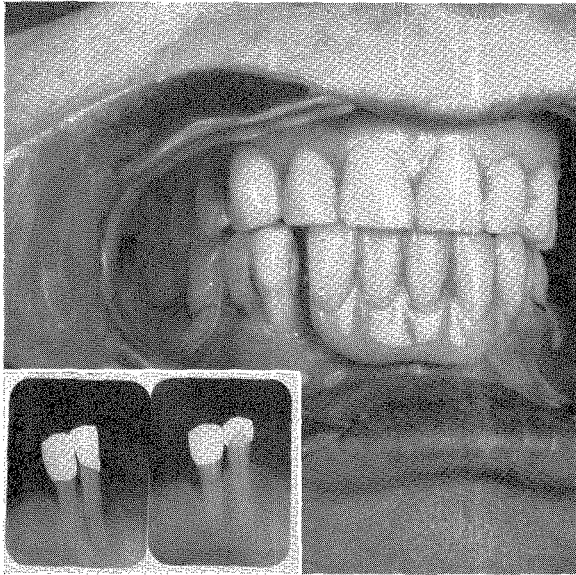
The mouth as it looked in October, 1950. In the insert are roentgenograms taken in October, 1950.
